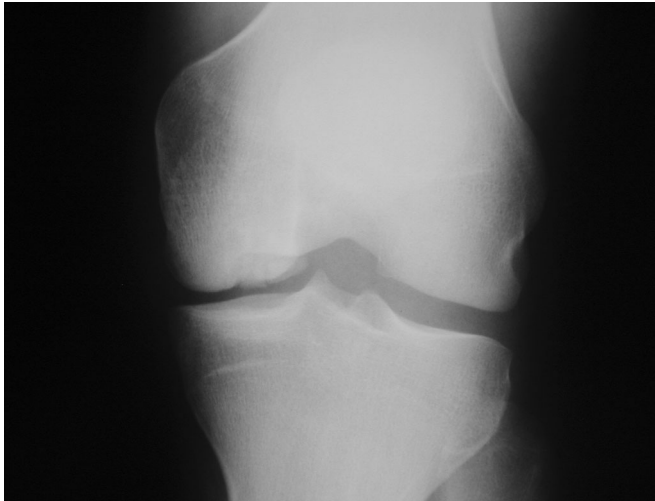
An AP radiograph demonstrating osteochondritis dissecans lesion with subchondral bone involvement on the lateral aspect of the medial femoral condyle.
